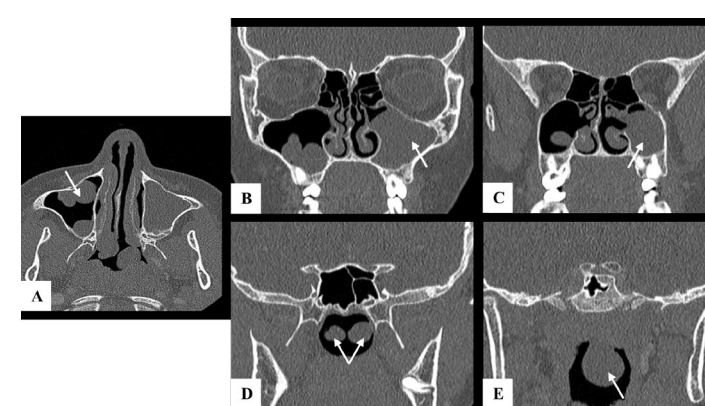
Axial (A) and coronal (B-E) CT scan of the sinuses showing bilateral antrochoanal polyps that extended from each maxillary sinus into the nasopharynx (D) on the right and the oropharynx (E) on the left. White arrows indicate polyps.
